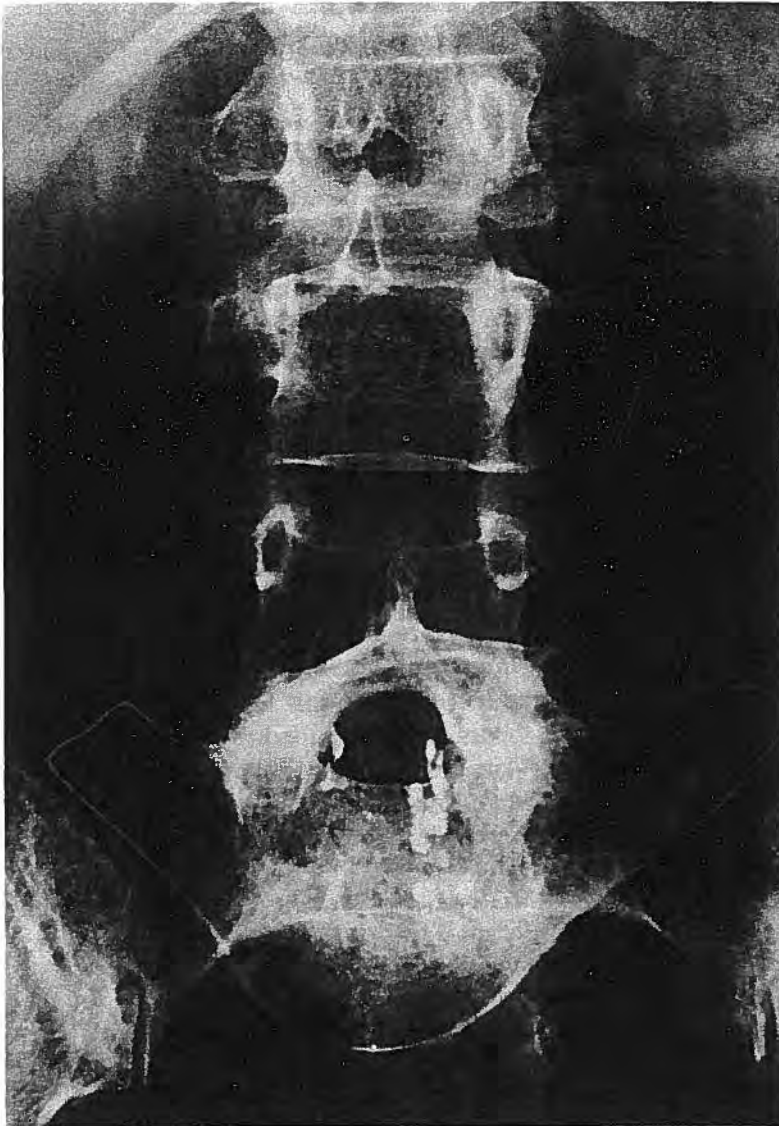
An antero-posterior radiograph of the lumbar spine of a woman aged 53, with spondyloptosis of L5. Note the classical radiological sign of "Napoleon's Hat". At operation, identification of vertebral levels can be difficult in such cases. Despite two operations aimed at decompressing the lumbar canal and nerve roots related to the spondyloptosis, the lamina of L5 remains intact. However, the laminae of L2 and L3 have been removed, along with some of their related facets
